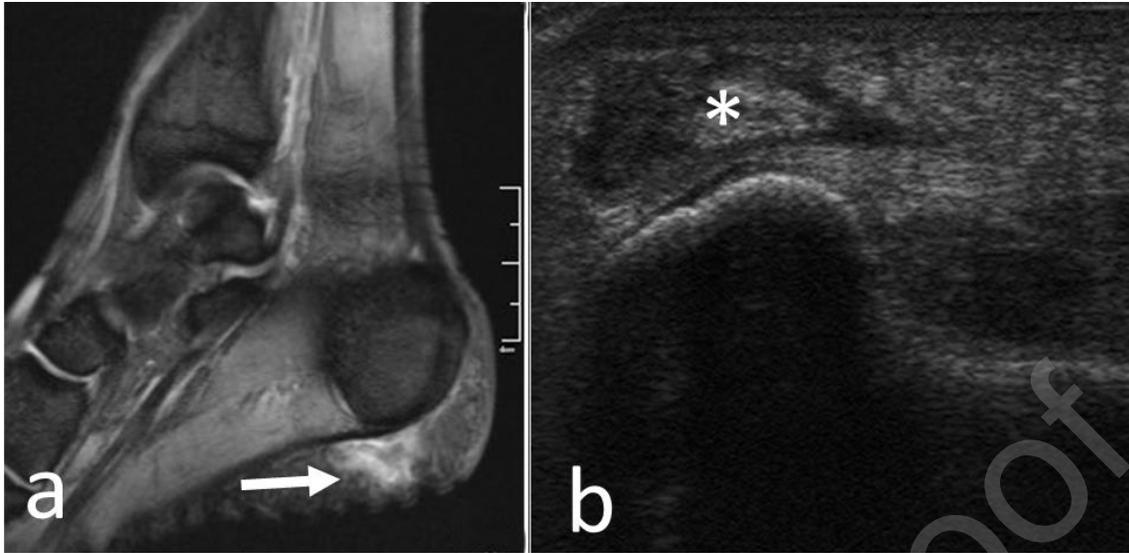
Heel fat with defect (arrows) and septal free tissue (*) (case 1). Sagittal MRI T2 (a). Long-axis (b) ultrasonography without probe pressure with dense material observed.
